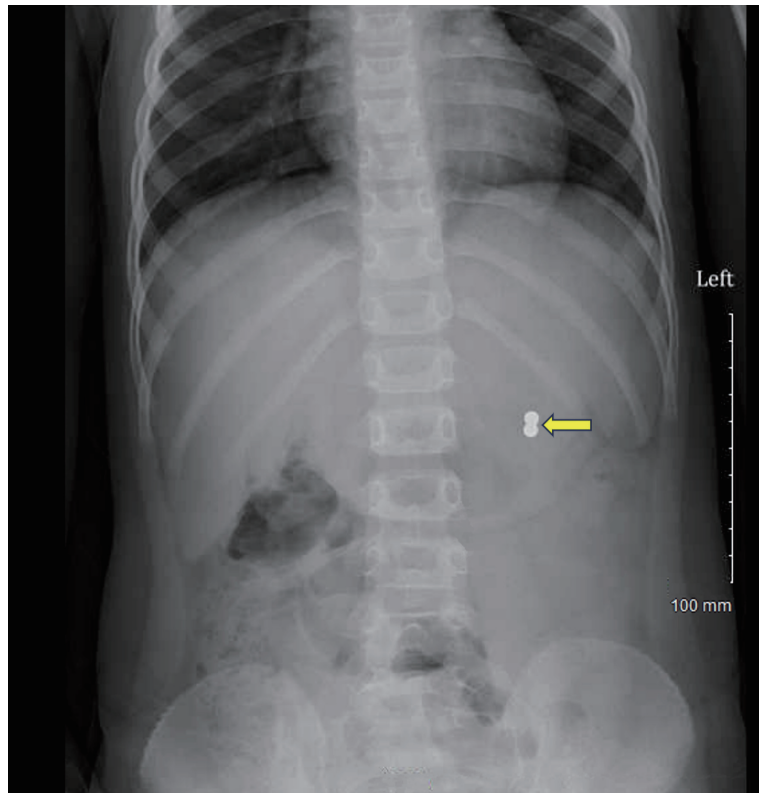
A radiograph showing two 4-mm ball bearing magnets within the stomach (yellow arrow).
